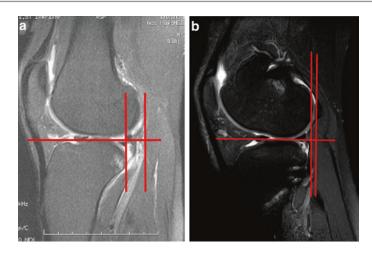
a Pre-operative sagittal MRI image of the anterior tibial translation value was 14 mm; b post-operative sagittal MRI image of the anterior tibial translation value was 1 mm at 2-year follow-up visit
